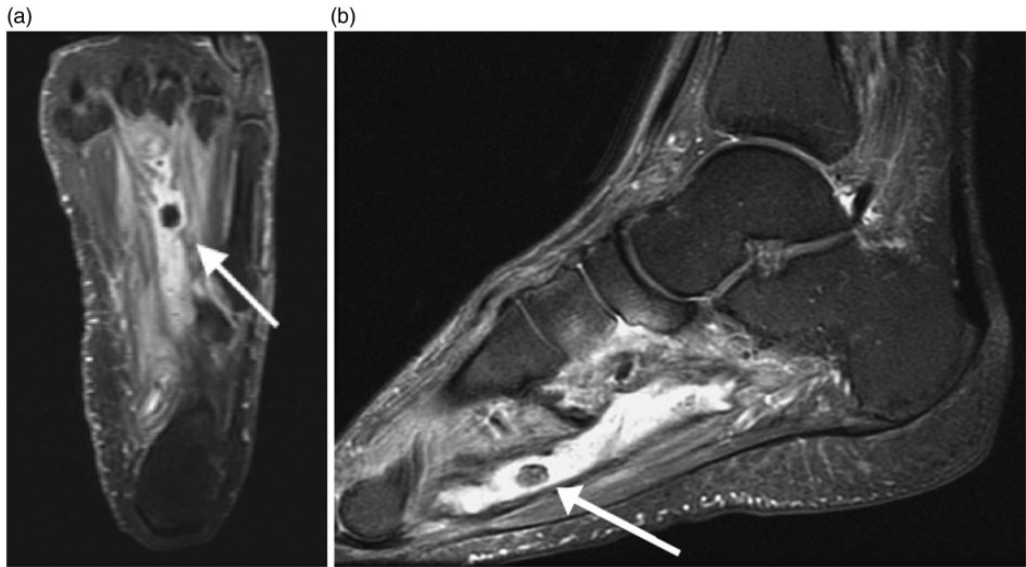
Magnetic resonance imaging (MRI) scan of the foreign body. Fluid accumulation was noted along the plantar fascia with a hypointense lesion observed on both T1-weighted (TIW) and T2-weighted (T2W) images without enhancement (arrows).
